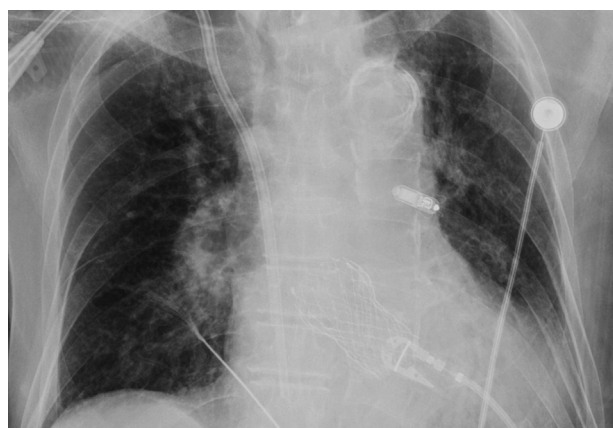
Chest radiograph. The Micra leadless cardiac pacemaker (Medtronic Inc, Minneapolis, MN) is dislodged to the left pulmonary artery.
